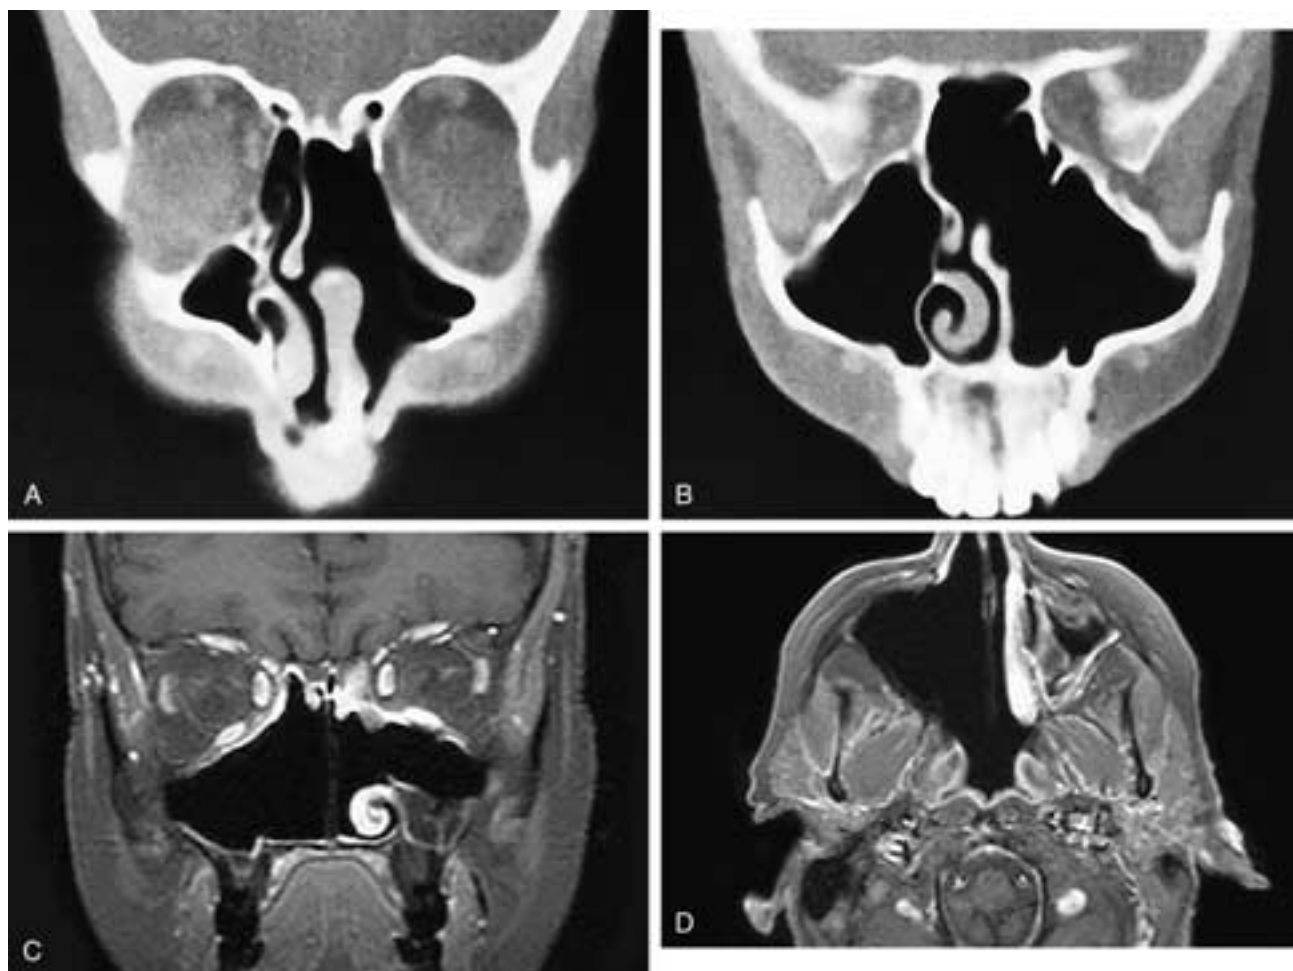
Coronal CT scan through the anterior antrum (A) and posterior antrum and sphenoid sinus (B) in a patient who has had a left lateral rhinotomy. There has been a left ethmoidectomy and a medial maxillectomy. The upper nasal septum has also been removed. This is the typical appearance of this operative procedure. Coronal (C) and axial (D) T1-weighted, fat-suppressed, contrast-enhanced MR images of another patient who has had a lateral rhinotomy including a right total maxillectomy and ethmoidectomy and a left medial antrostomy and a partial ethmoidectomy. Note the absence of any focal enhancing nodules.
